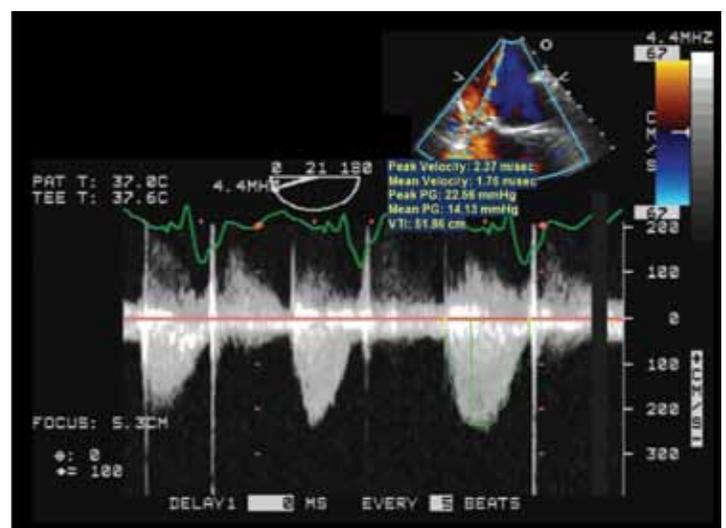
Doppler recordings of the obstructed tricuspid valve. Peak and mean gradients were 22 and 14 mmHg respectively.
